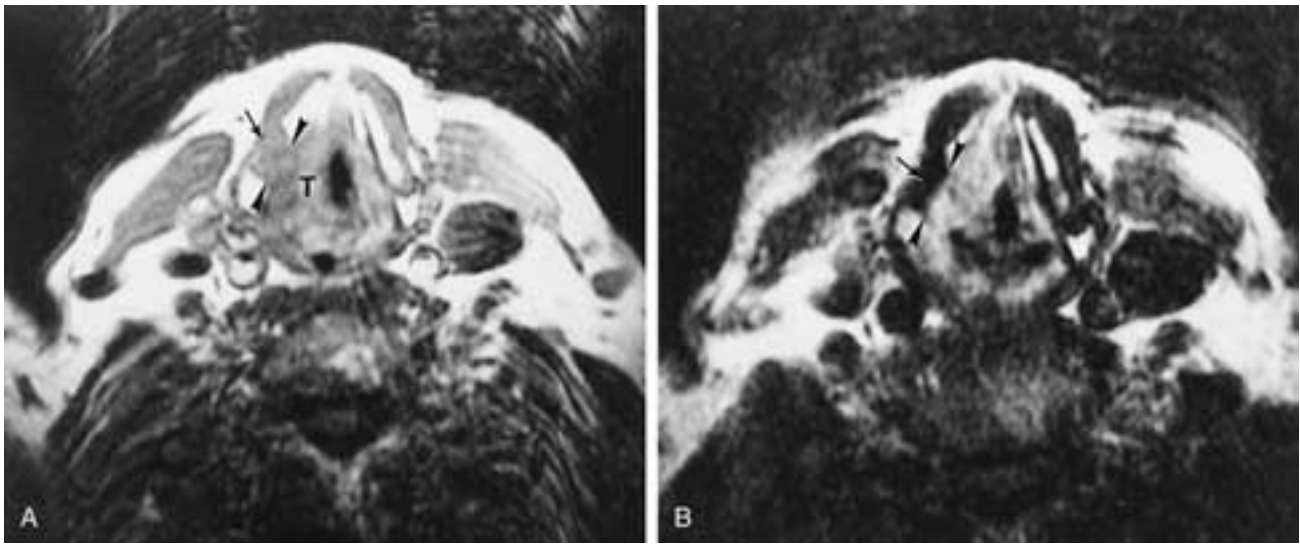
Axial MR image shows tumor against nonossified cartilage. A, T1-weighted image shows that tumor (*T*) and nonossified cartilage (*arrow*) both have intermediate signal intensity, and the tumor-cartilage junction between the arrowheads cannot be defined. B, T2-weighted image shows brightening of the tumor. The nonossified cartilage does not brighten (*arrow*). The margin between tumor and cartilage is now clearly defined (*between arrowheads*).
